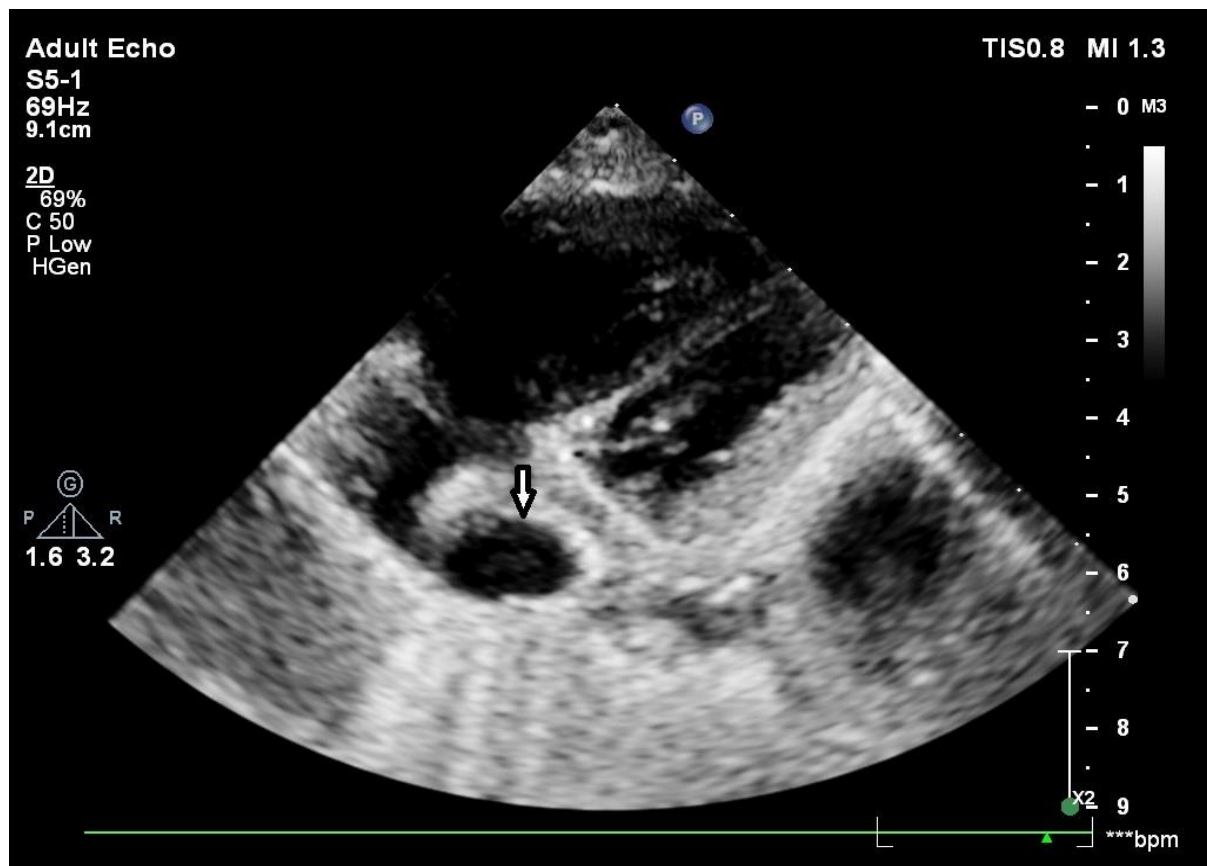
Echocardiography (PSAX view). The white arrow shows right atrial thrombus.
